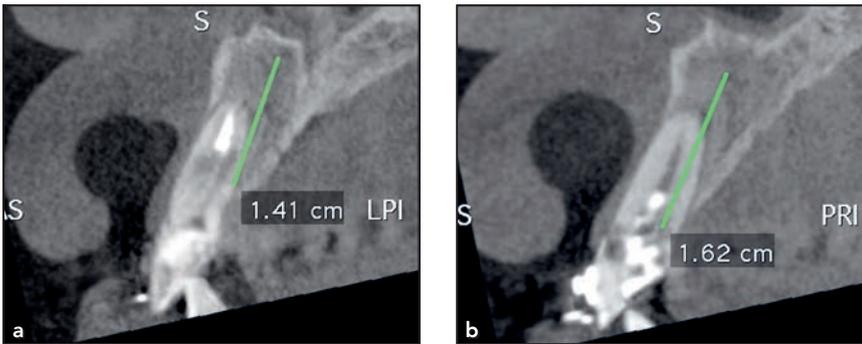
CBCT scans showed the thin buccal bone plate of (a) tooth 12 and (b) tooth 22.
